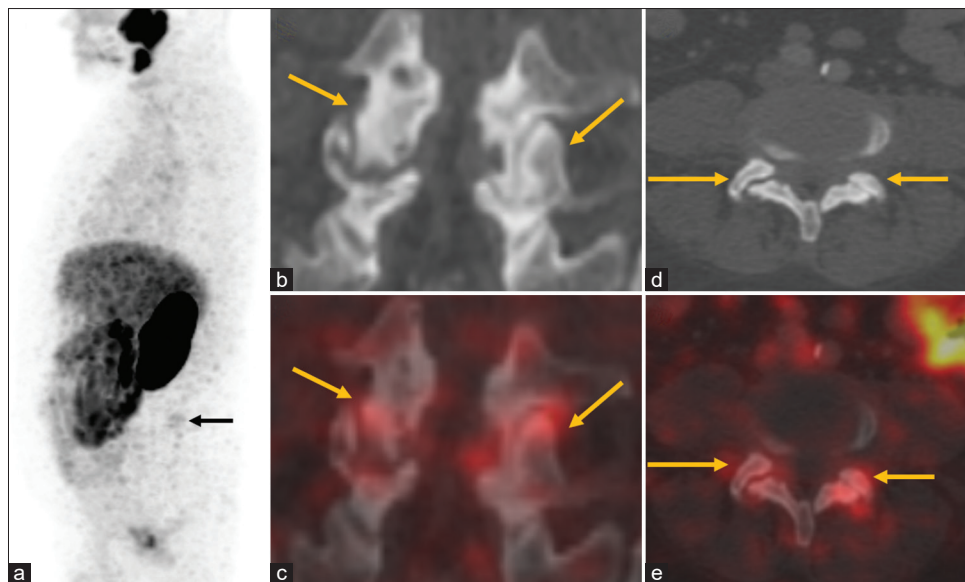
This is a case of a 70-year-old male with newly diagnosed adenocarcinoma prostate with Gleason score of 4+4=8 and a serum PSA of 6.5ng/ml. Baseline 68Ga PSMA PET/CT scan shows low grade tracer uptake (SUVmax 2.3) in bilateral facet arthropathy involving L4-L5 and L5-S1 intervertebral facets displayed in the MIP (image a, black arrow), coronal and axial planes of CT (b & d; arrows) and fused (c & e; arrows) images, respectively
